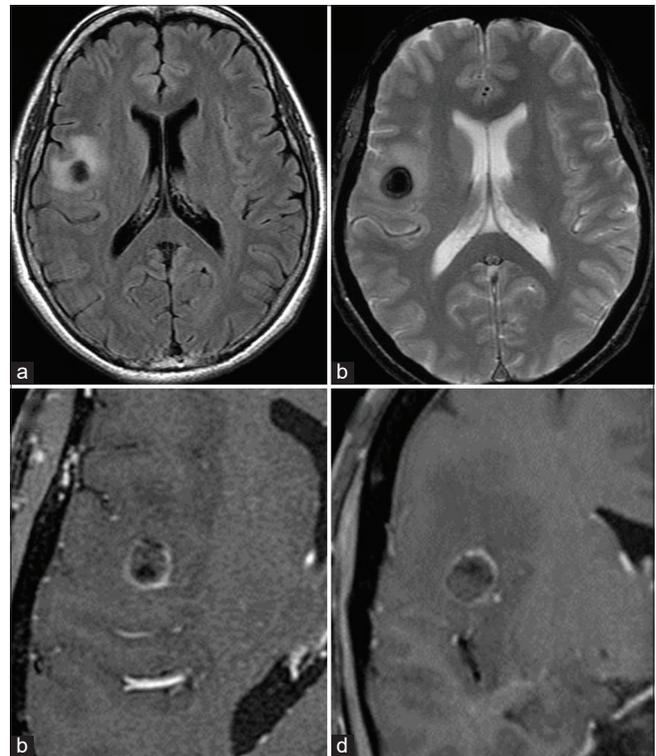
(a) Fluid-attenuated inversion recovery axial magnetic resonance imaging (MRI). (b) T2-weighted axial MRI. (c) Gadolinium-enhanced T1-weighted axial MRI. (d) Gadolinium-enhanced T1-weighted coronal MRI. A round mass with surrounding edema is noted in the right frontal lobe. T2-weighted image shows dark signal intensity due to hematoma. Gadolinium-enhanced T1-weighted images show ring enhancement, suggesting intra-axial neoplasm as a differential diagnosis.
